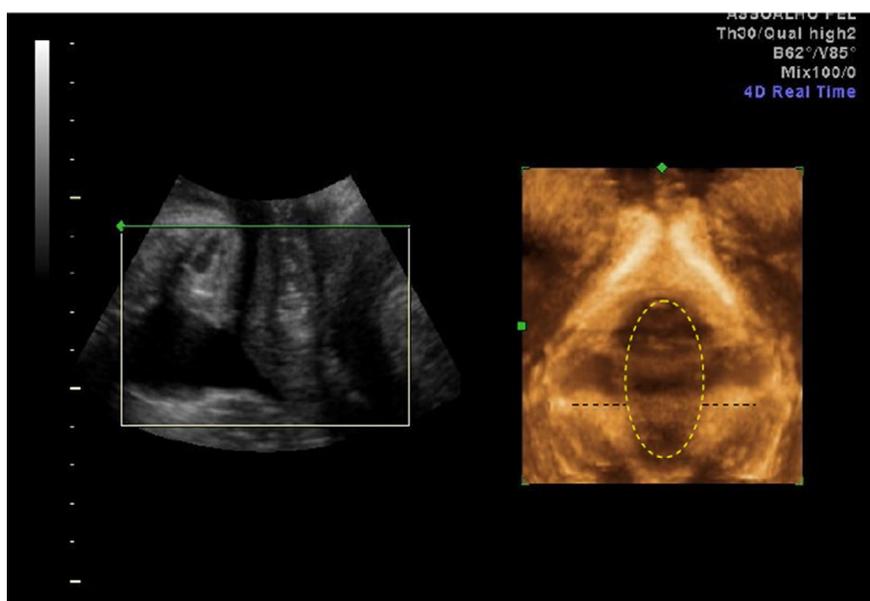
Three-dimensional ultrasound at rest in sagittal view (left) and axial (right). The yellow ellipse represents the genital hiatus measurement at rest. The dashed lines represent thickness measurements of the puborectalis muscle bilaterally (05 and 07 h)
